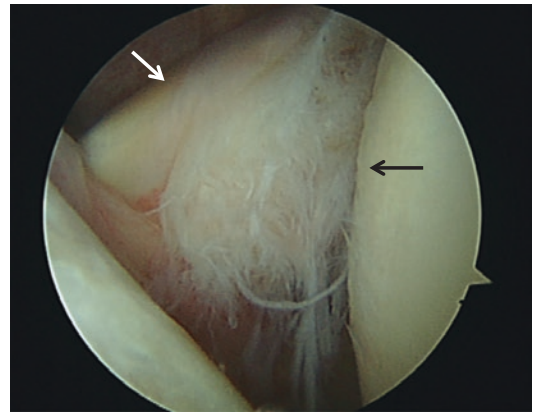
(a–c) Combined partial- and full-thickness tear of supraspinatus tendon. Double-oblique coronal PD-weighted MR images with intra-articular contrast (a, b) demonstrate partial tear at articular side (black arrow), focally full thickness (white arrow) extending to subacromial space (c)
